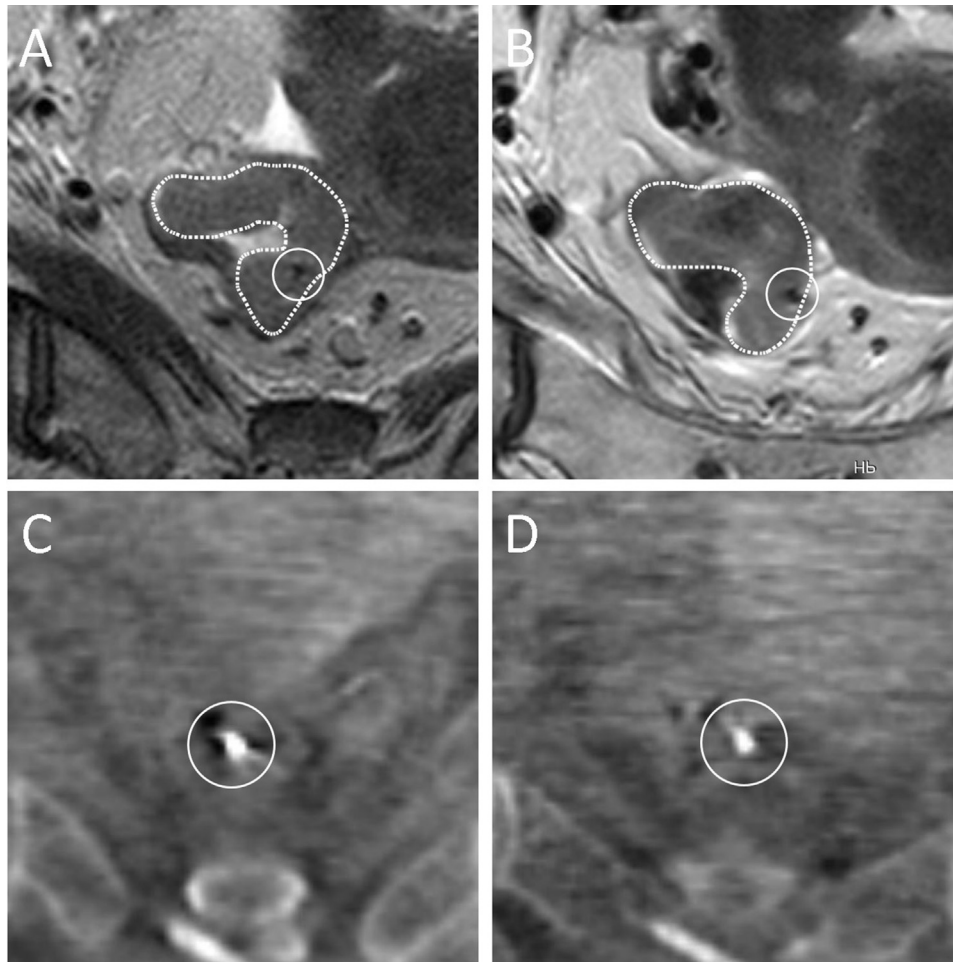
(A) and (B) examples of a gross tumor volume delineation and a fiducial on the T2-TSE sequence of both magnetic resonance imaging examinations and (C) and (D) the same fiducial on 2 preirradiation cone beam computed tomography scans for patient 19.
